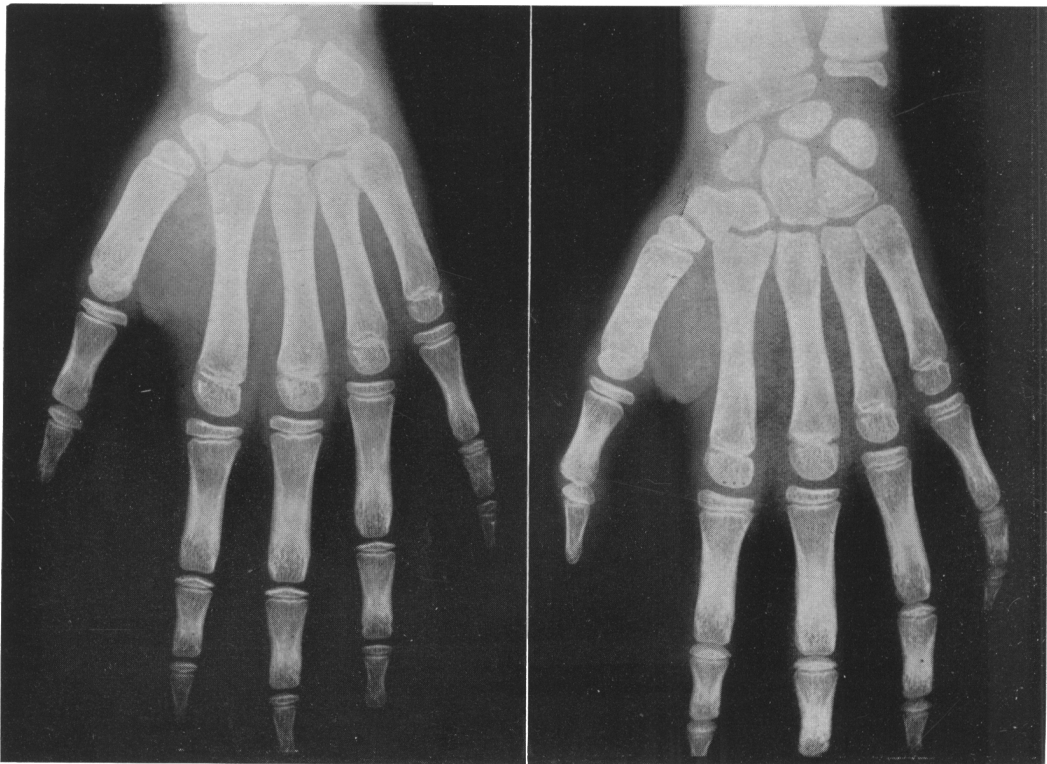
Comparative roentgenographic studies of the hands and wrists of both twins at age of 7 1/2 years. Maturation nearly equal and consistent with chronologic age. Twin No. 1, left; Twin No. 2, right
